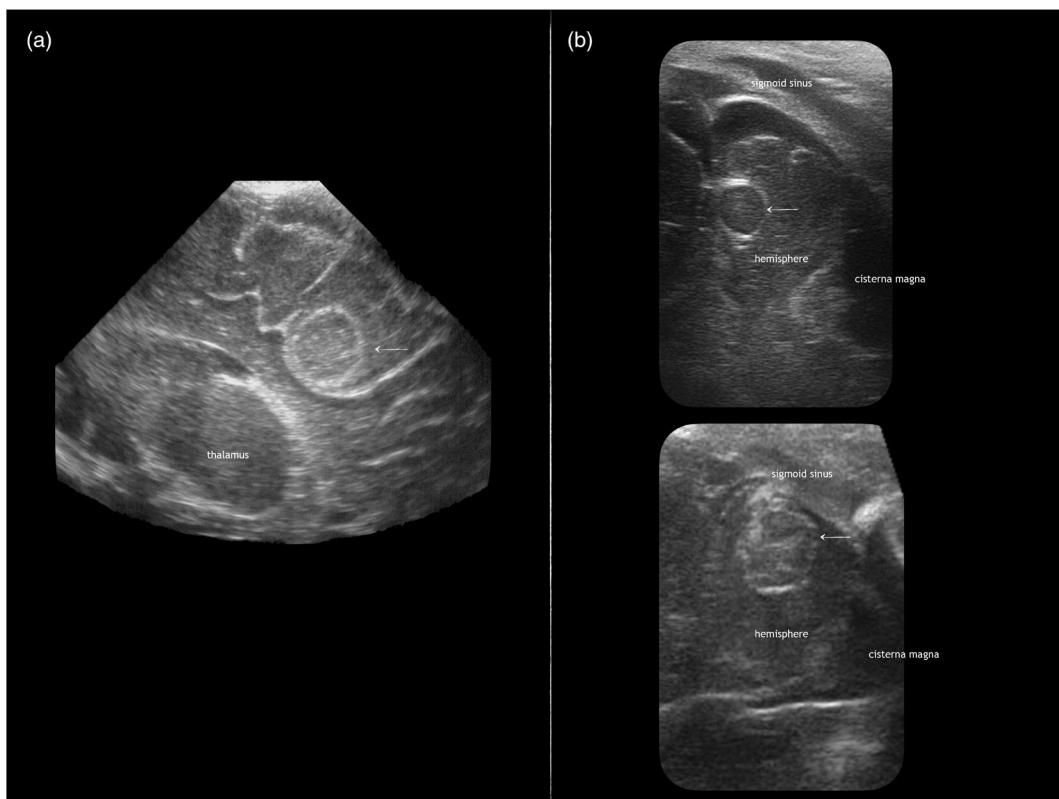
Staphylococcus aureus* abscess. (a) Cerebral abscess in the paracentral lobule with *S. aureus* in a term infant (parasagittal cranial ultrasound image). (b) Cerebellar abscess with *S. aureus* (two different infants born preterm, both with mastoid insonations).
